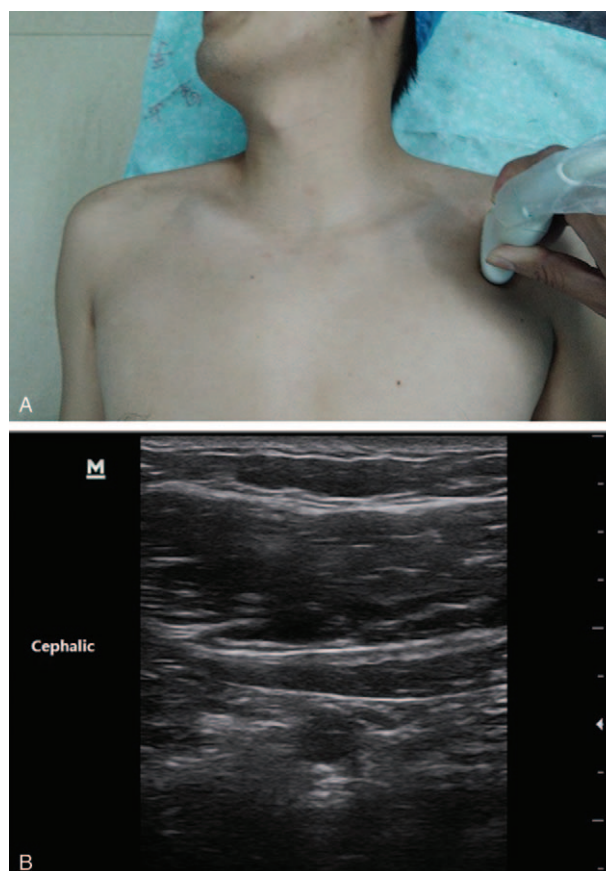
(A) The position and orientation of probe for CABPB. (B) The ultrasonic image for CABPB.
